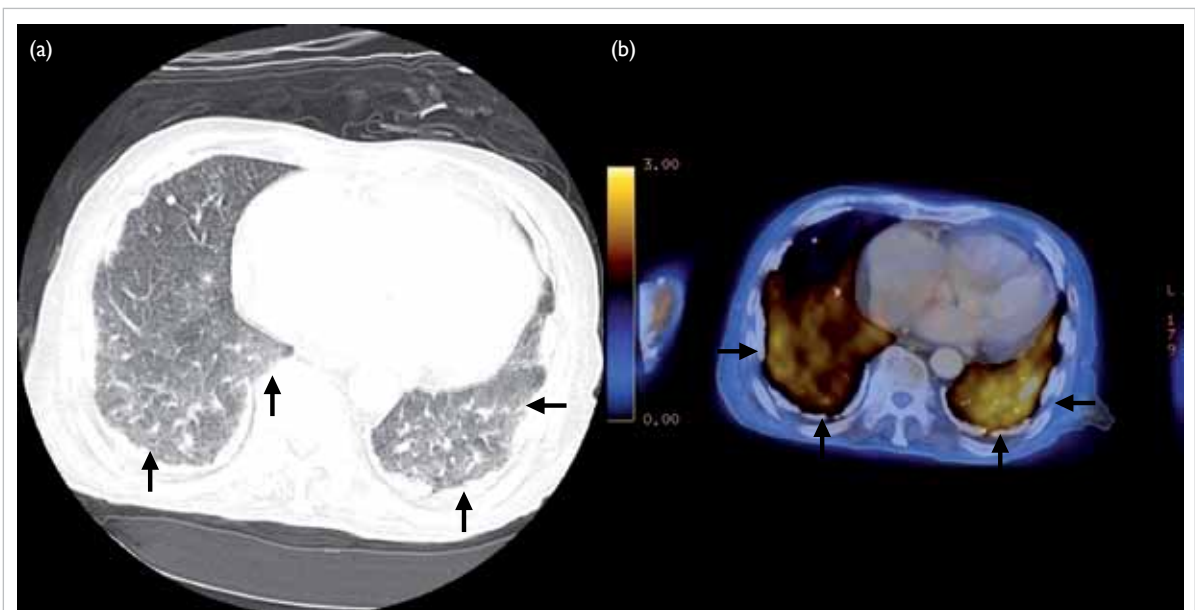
(a) Computed tomography thorax showing a background of calcified pleural plaques and an increase in patchy ground glass opacities over both lower lobes (arrows). (b) Positron emission tomography-computed tomography showing the parenchymal pattern of increased <sup>18</sup>fluorodeoxyglucose uptake (maximum standardised uptake values of up to 4) over the both lower lobes (arrows)
